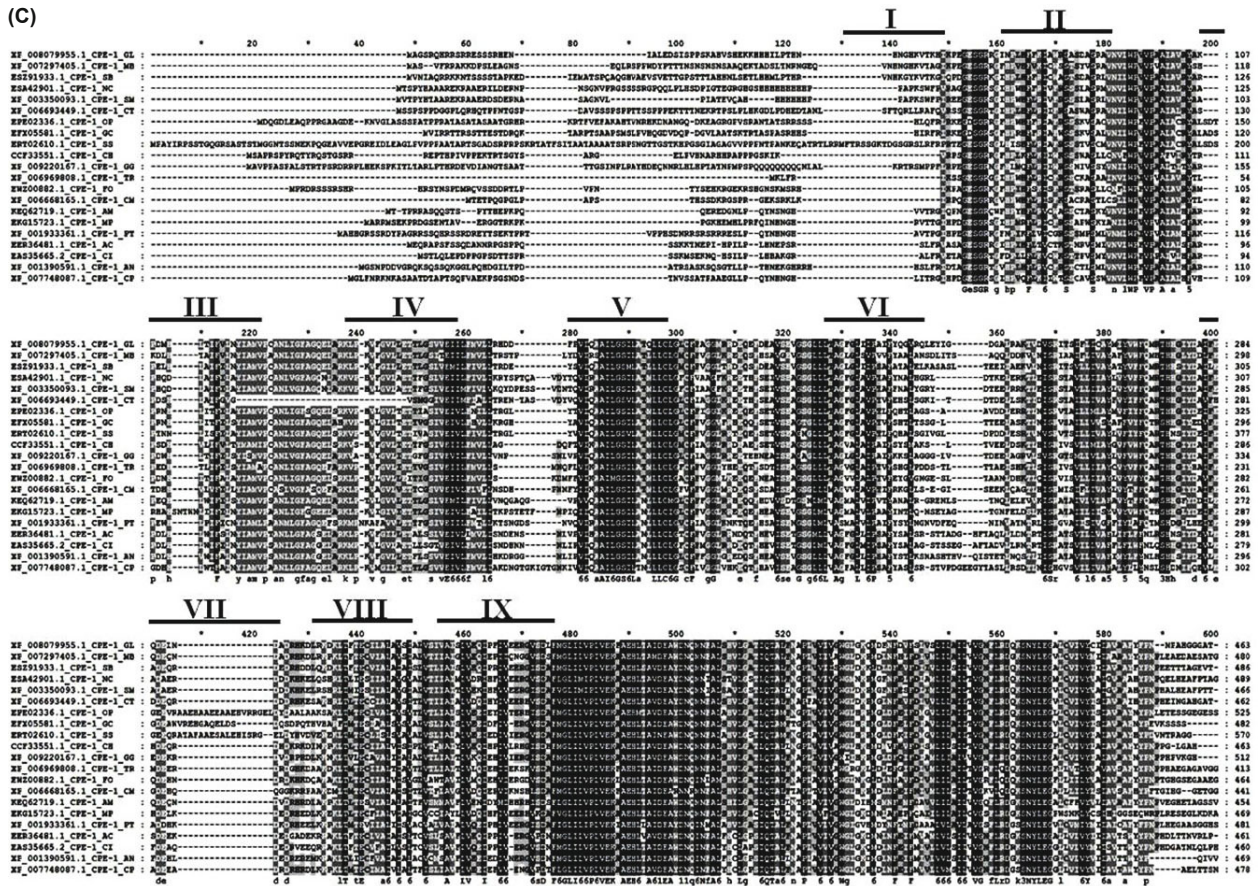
Sequence analysis of *plc-1*, *spla2*, and *cpe-1* homologues. (A) Sequence alignment of PLC-1 homologues. The positions of the hydrogen binding residues are indicated above the sequence (inverted triangles) and the Ca²⁺ binding residues are indicated below the sequence (filled triangles) (Chung *et al.*, 2006). (B) Sequence alignment of sPLA2 homologues. The predicted secretion signal peptide is underlined in red. The highly conserved portion of sPLA2 (positions 122-153) is underlined in black. The positions of the catalytic histidine residue (open circle) and disulphide bonded cysteine residues (filled triangles) are indicated below the sequences (Soragni *et al.*, 2001). (C) Sequence alignment of CPE-1 homologues. The sequence corresponds to transmembrane segments (I to IX) as predicted with TMHMM program are shown underlined (<http://www.cbs.dtu.dk/services/TMHMM/>) (Zelter *et al.*, 2004; Guttery *et al.*, 2013). The sequences used in the analyses are AC, *A. capsulatus*; ArC, *Acremonium chrysogenum*; AM, *Aureobasidium melanogenum*; AN, *Aspergillus niger*; AO, *A. oryzae*; BB, *Beauveria bassiana*; CF, *Colletotrichum fioriniae*; CH, *C. higginsianum*; CI, *Coccidioides immitis*; CM, *Cordyceps militaris*; CP, *Cladophialophora psammophila*; CrP, *C. parasitica*; CvP, *Claviceps purpurea*; CT, *Chaetomium thermophilum*; FO, *Fusarium oxysporum*; GC, *Grosmannia clavigera*; GG, *Gaeumannomyces graminis*; HN1, *Helicosporia* sp.; GL, *Glarea lozoyensis*; MA, *Metarhizium anisopliae*; MB, *Marssonina brunnea*; MO, *M. oryzae*; MP, *Macrophomina phaseolina*; MT, *Myceliophthora thermophila*; NC, *N. crassa*; NH, *Nectria haematococca*; OP, *Ophiostoma piceae*; PA, *Podospora anserine*; PB, *Paracoccidioides brasiliensis*; PO, *Pyronema omphalodes*; PT, *Pyrenophoratrifici-repentis*; SA, *Scedosporium apiospermum*; SB, *Sclerotinia borealis*; SM, *Sordaria macrospora*; SS, *Sporothrix schenckii*; TB, *T. borchii*; TE, *Trichophyton equinum*; TR, *Trichoderma reesei*; VA, *Verticillium alfalfae*; VD, *Verticillium dahliae*; VV, *Villosiclava virens*. Conserved amino acids are indicated in black (100%), dark grey (>80%) and light grey (>60%) in the alignments.
